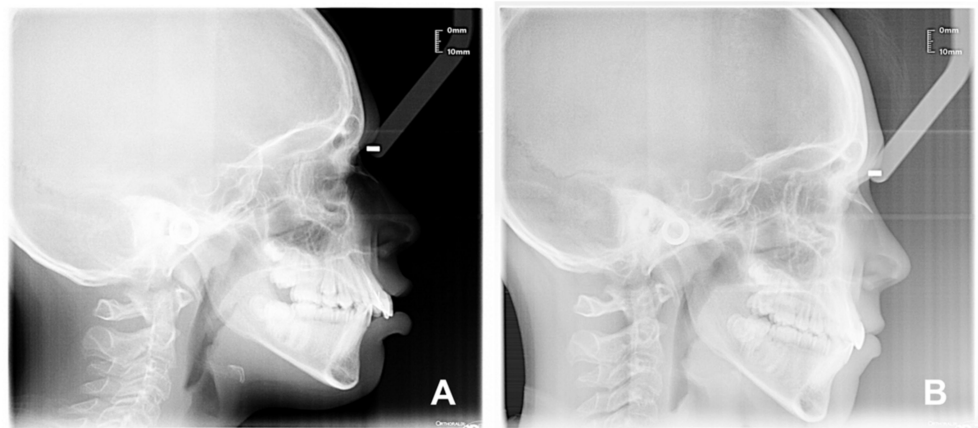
(A,B)—Patient (V.M.) latero-lateral teleroadiography X-ray: before treatment T0 (A); and after treatment T1 (B).
